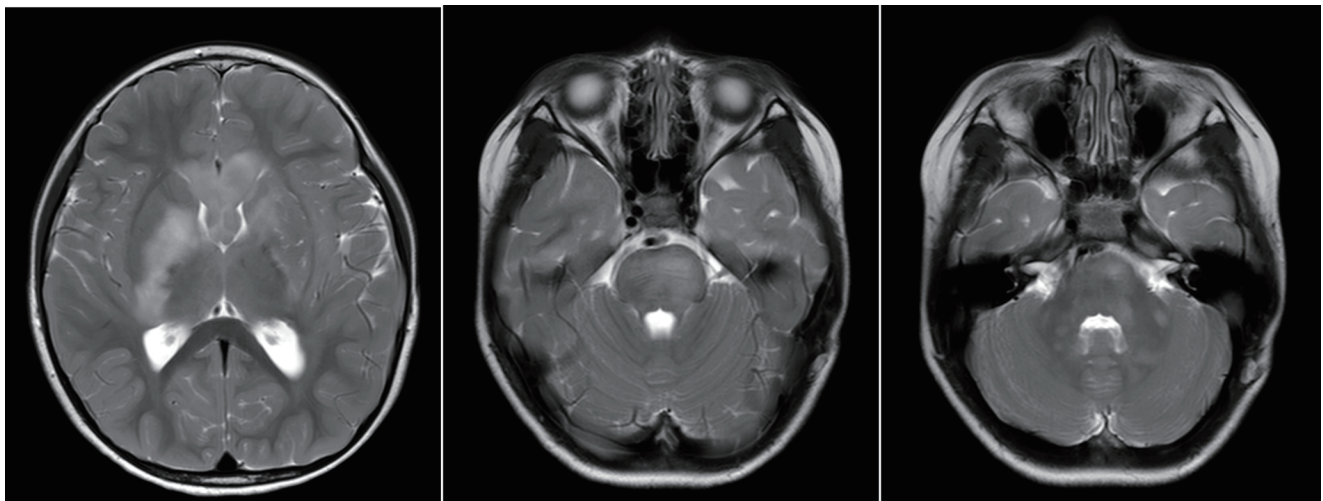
Brain magnetic resonance (MR) imaging of a 4-year-old female with neurofibromatosis type 1 (NF1) showing optic pathway glioma (OPG) and focal areas of signal intensity (FASI). T2-weighted axial MR images demonstrate an OPG extending to the fornix (left image). Additionally, multiple FASIs are present in the right corona radiata and internal capsule (left), pons (center) and cerebellar peduncle (right), which are commonly observed in NF1 patients.
